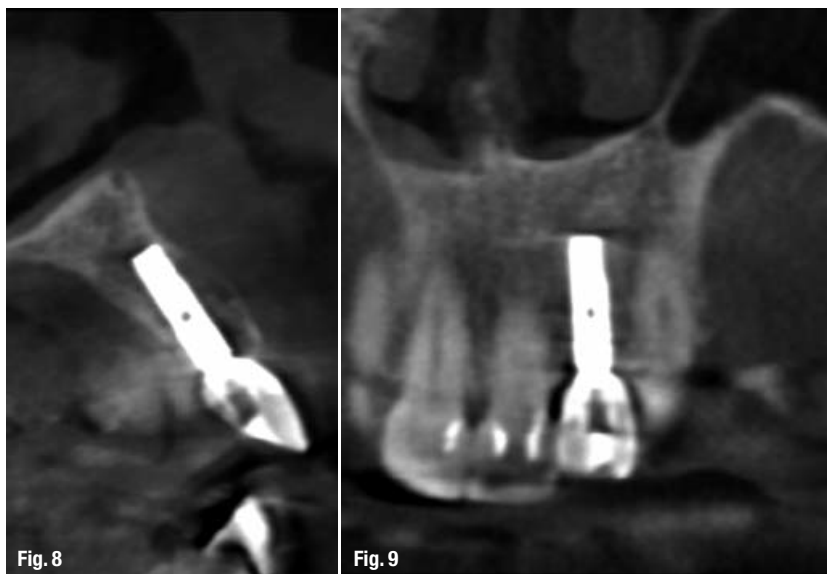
Post-implant cross-sectional CBCT image demonstrating good position and angulation in relationship to provisional prosthesis.
